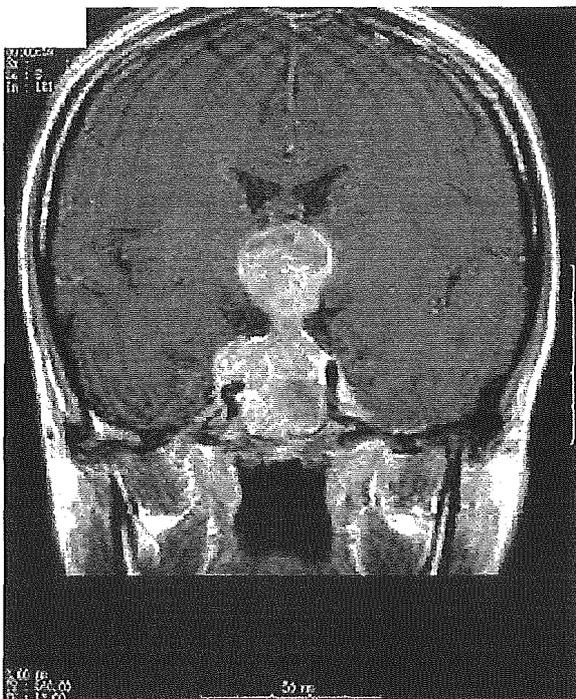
MRI of the brain (coronal, T1-weighted), with gadolinium enhancement before RT. There was a tumor from clivus to sella turcica and suprasellar region with internal necrosis or cystic component. There was a slight segmented tumor. Its diameter was $3.5 \times 3 \times 6.5$ cm. The solid component was enhanced highly. In the right side, it also invaded cavernous sinus and encased right distal internal carotid artery. There was an epidural hematoma just under frontal craniotomy region. The postoperative change along with dura was remarkable too. There was no hydrocephalus.
